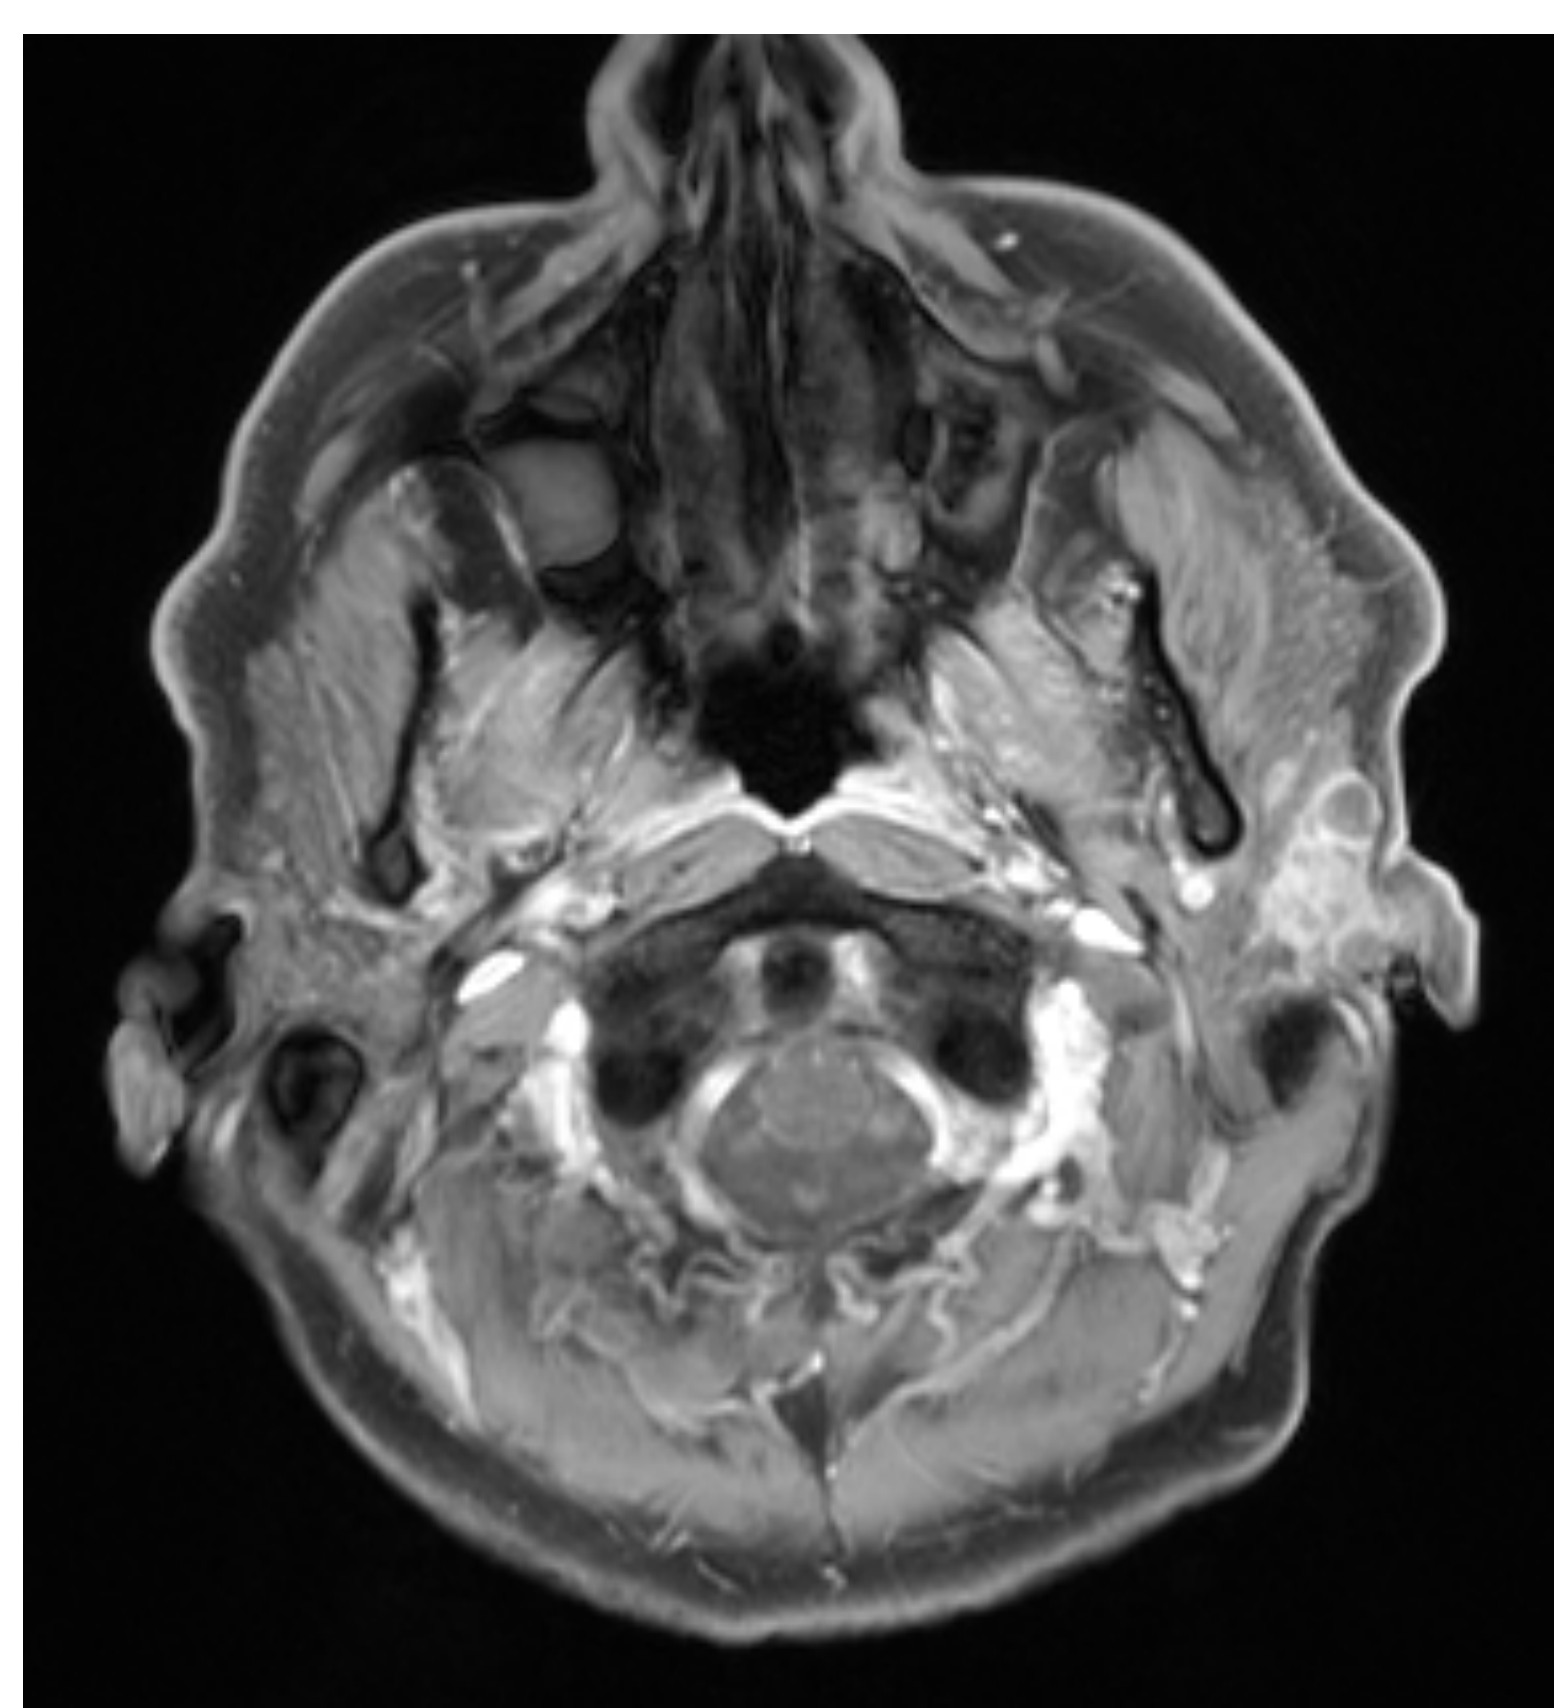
MRI, axial image through left parotid showing a solid and cystic mass with post-auricular cutaneous extension
